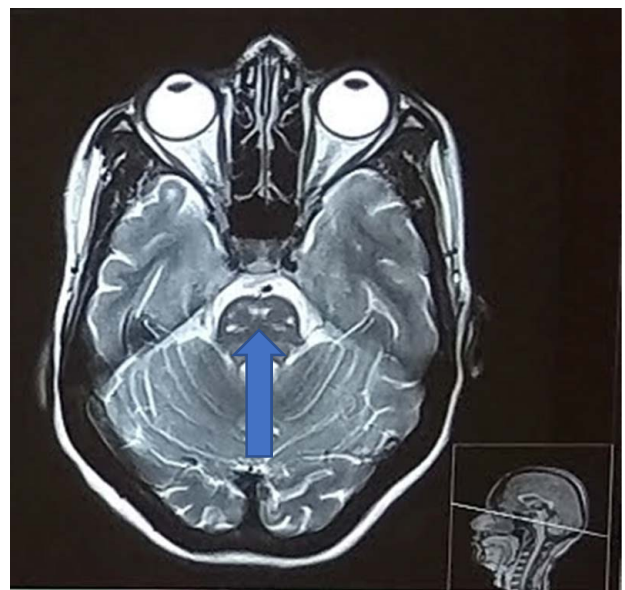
T2-weighted image showing high signal intensity lesion in pons.
